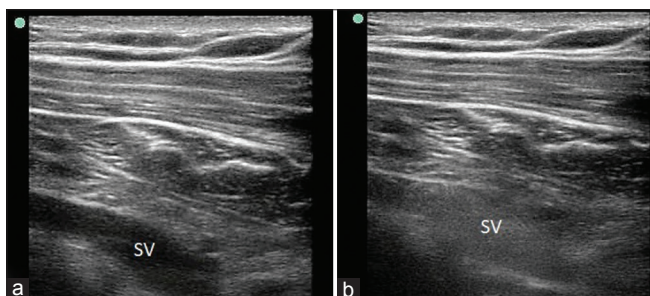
(a) Subclavian vein seen in long axis with ultrasound probe placed infra-clavicularly. (b) Microbubbles due to turbulence (swirl sign) noted within the subclavian vein following a rapid saline flush
